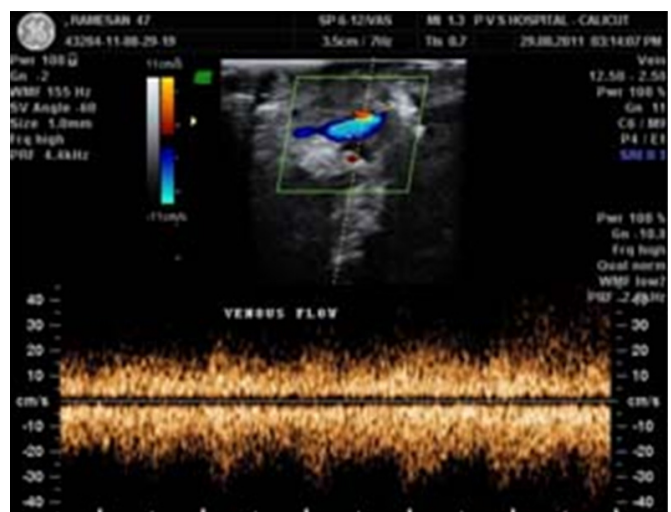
Doppler study of lingual varix with typical flow pattern
